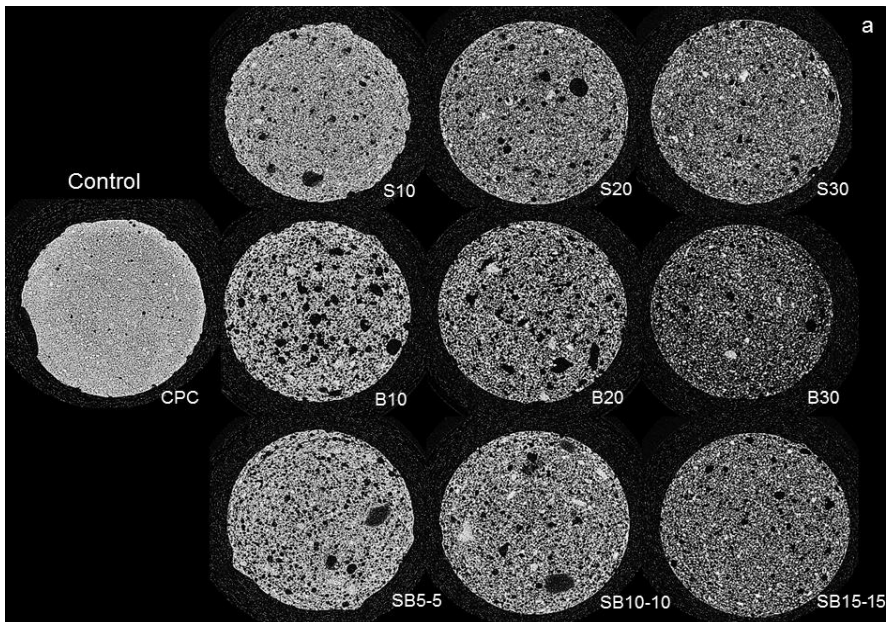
Representative μ -CT cross-sections, 4.5 mm in diameter, of the different basic CPC-PLGA samples. S: Small particles ($\approx 20 \mu\text{m}$). B: Big particles ($\approx 40 \mu\text{m}$) and SB: Mixture of small and big particles. Numbers next to prefixes are the weight percentages of PLGA loaded into the CPC.
